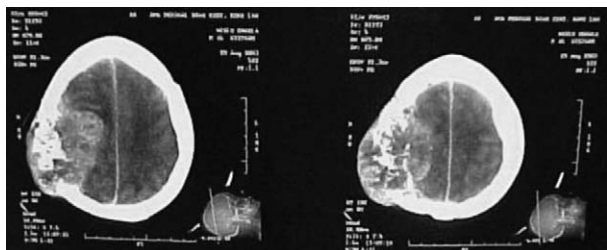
A contrast-enhanced computed tomography (CECT) film showing a large heterogeneous lesion with post-contrast enhancement in the right parietal lobe along with a destructive expansile parietal bone lesion with a soft tissue component of the right scalp suggestive of brain and scalp metastases.
